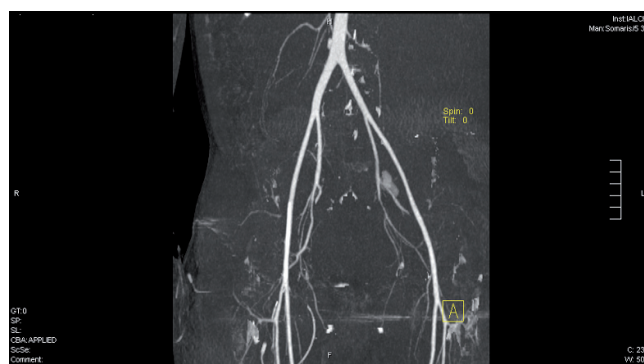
CT angiogram showing a false aneurysm and extravasation from the left superior gluteal artery.
